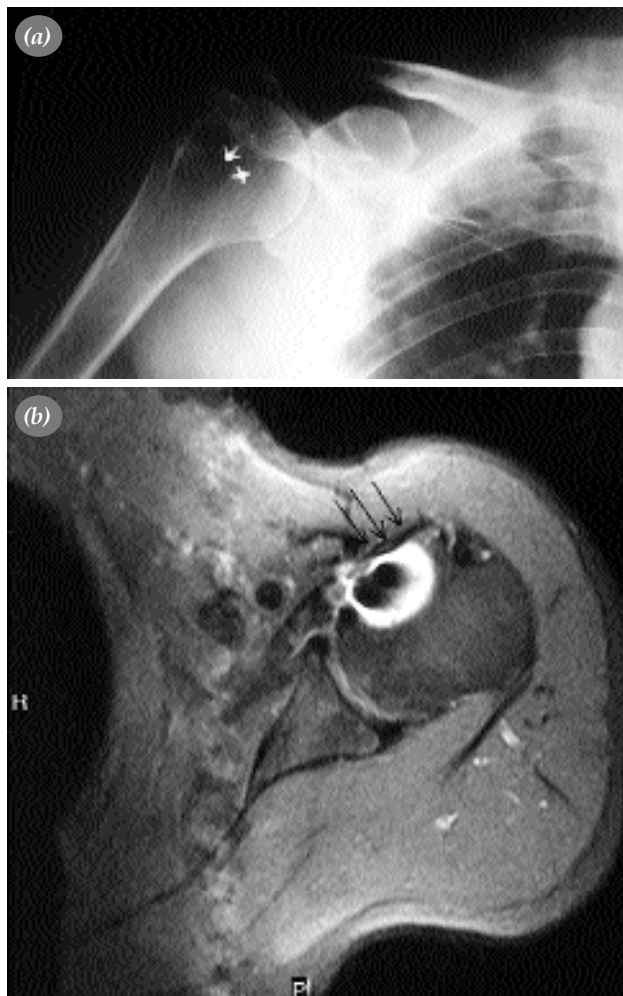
(a) Radiography obtained during last control (b) In the MR image, it is seen that the subscapularis tendon continuity is preserved.
